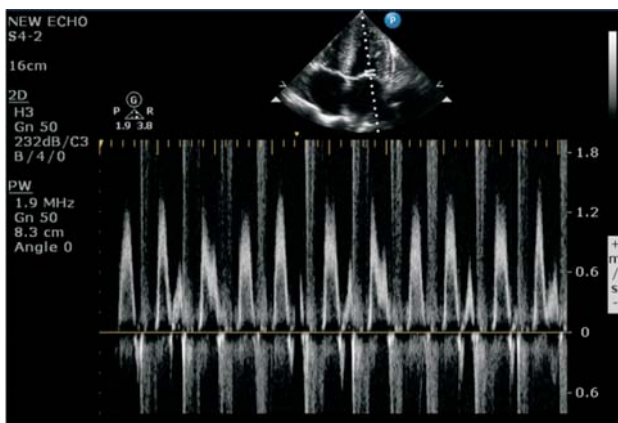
Mitral valve inflow velocity on pulsed wave Doppler showing <25% variation.
